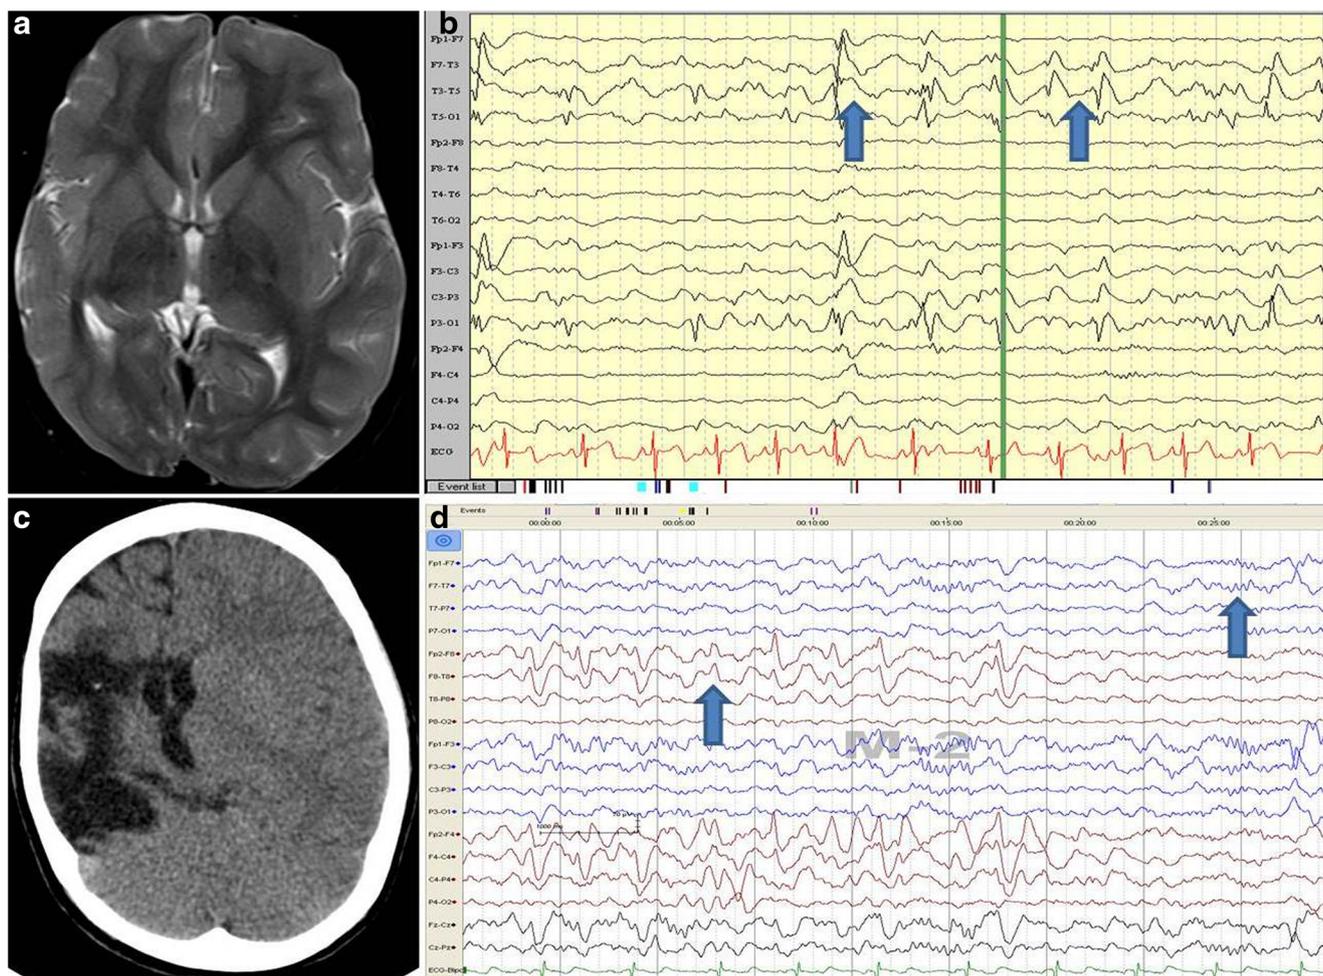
The preoperative a MRI and b EEG along with the postoperative c CT scan and d EEG of a 7-year-old girl with right hemispheric dysplasia. In children with long-standing hemispheric pathology resulting in parenchymal volume loss, epileptiform activity may not be picked up by the ipsilateral leads causing the preoperative EEG to show only contralateral abnormalities (arrows in b), as is noted in this patient. As a result, differentiating between transmitted epileptiform activity from the diseased
